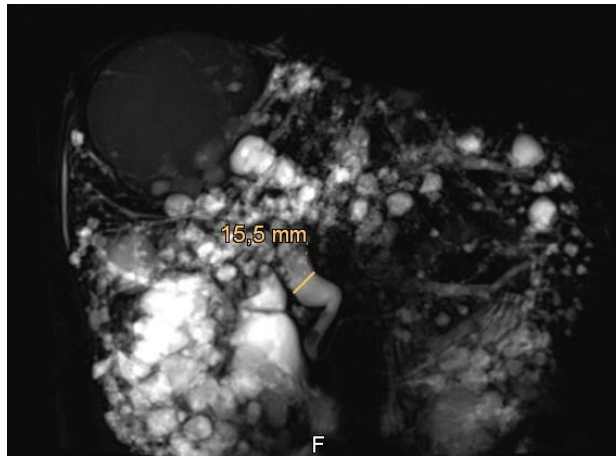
Hepatic MRI with BILI sequences showing dilation of the common bile duct with a stone in the distal common bile duct
